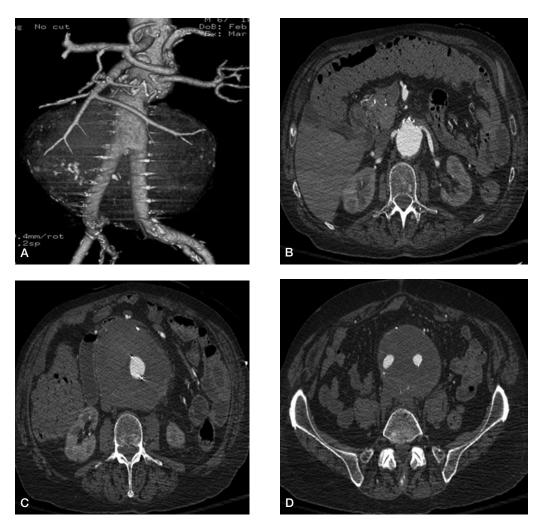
A. A 3-D CT angiogram demonstrating a 12-cm AAA 9 years following initial Ancure placement. B-D. Axial cuts demonstrating the same AAA without gross evidence of an endoleak. The patient went on to open conversion, at which time several type II lumbar endoleaks were discovered.
